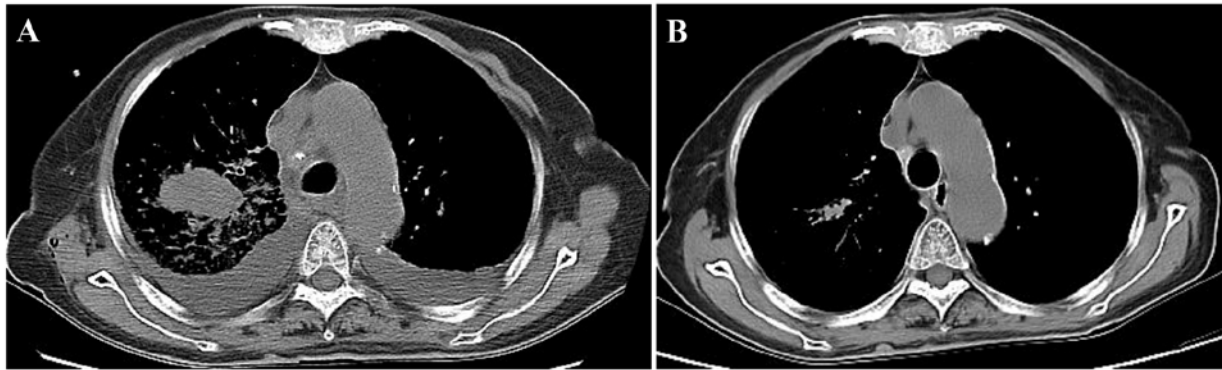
Chest contrast-enhanced CT scan before and after treatment. (A) Chest contrast-enhanced CT scan before treatment showed a mass in the right upper lobe pretreatment. (B) Chest contrast-enhanced CT scan showed that the mass had almost disappeared in the right upper lobe post-treatment. CT, computed tomography.
